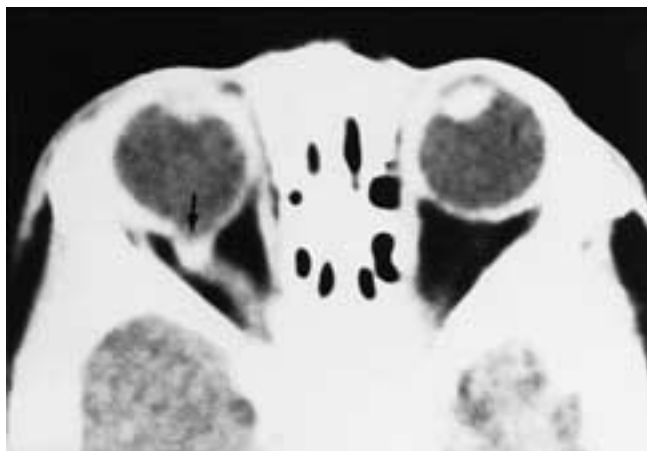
Typical coloboma of the optic disc. Axial CT scan shows a large posterior global defect (arrow) with optic disc excavation on the right side. The defect appears to be surrounded by an enhancing, deformed sclera and seems to have a direct connection with the vitreous body. (From Mafee MF et al. CT of optic nerve colobomas, morning glory anomaly, and colobomatous cyst. *Radiol Clin North Am* 1987; 25:693–699.)
